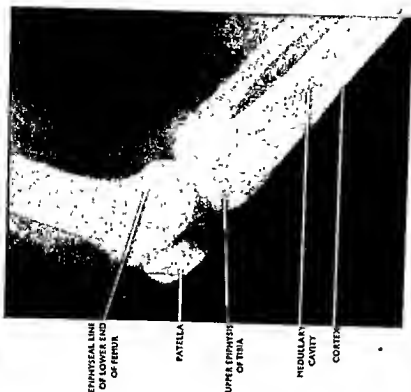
The lateral radiograph of the knee joint of a young adult. Explanatory notes. Note the epiphysal scar at the upper end of the tibia and at the lower end of the femur. Note also the position of the patella in relation to the femoral condyles in semiflexed position of the knee joint.
